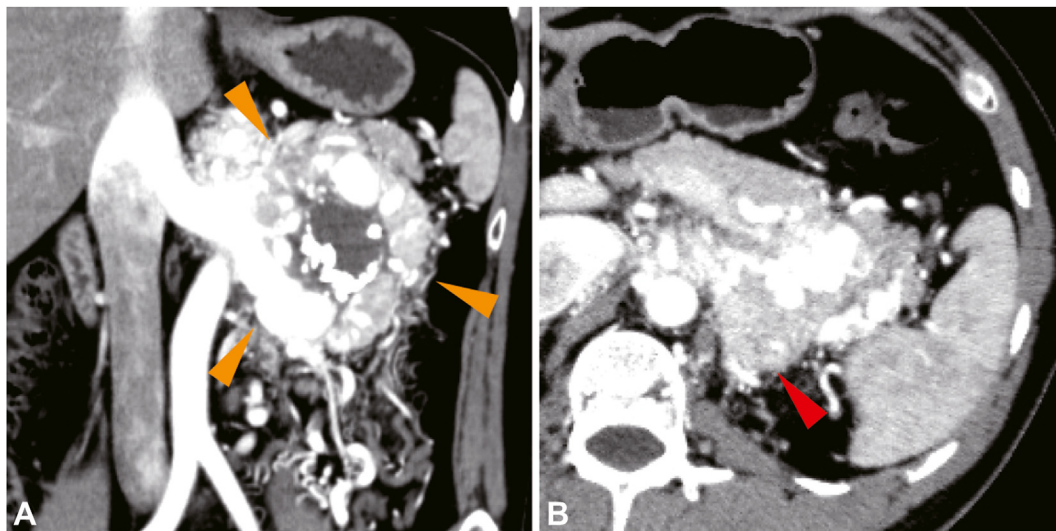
A, A 90-mm tumor (*orange arrow*) exhibiting significant vascular proliferation and calcifications was observed adjacent to the left kidney on contrast-enhanced CT. B, A few distinct solid lesions (*red arrow*) are observed on the cephalic and dorsal aspects of the tumor.
